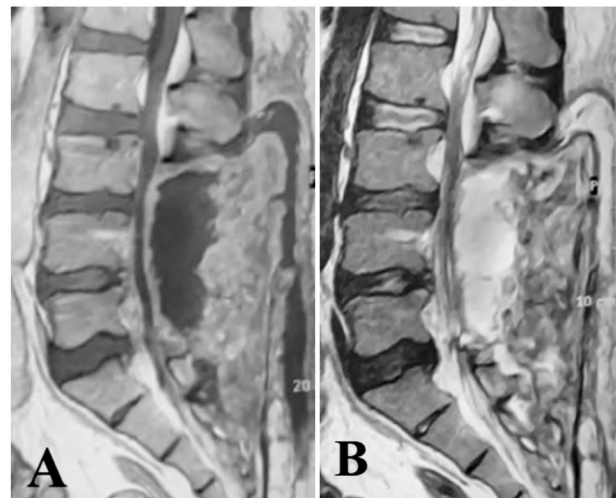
Sagittal magnetic resonance images showing the pseudomeningocele; (A) Sequence T1 weighted image, (B) Sequence T2 weighted image.
